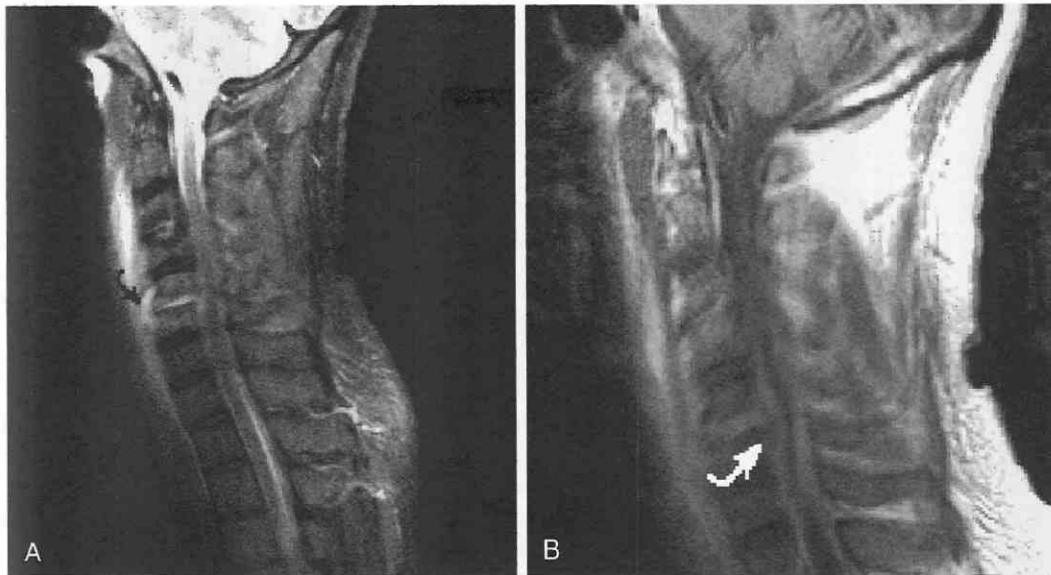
Cervical disk space infection with epidural abscess. *A*, T2-weighted sagittal image through the cervical spine. The C5-5 intervertebral disk space has increased signal, indicating the presence of diskitis. Although there is no evidence of adjacent marrow edema and the cortical margins are intact, a region of increased signal in the paraspinal soft tissues anterior to the interspace (arrow) indicates the presence of paraspinal cellulitis. *B*, T1-weighted sagittal image reveals contrast enhancement of the interspace, which confirms disk space infection. Thickening and enhancement of the meninges in the cervical spine and a small epidural fluid collection in the epidural space (arrow) indicate the presence of an epidural abscess.
